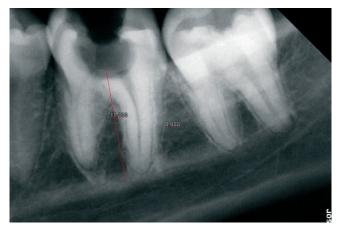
X-ray revealed a fracture related to tooth 46.
